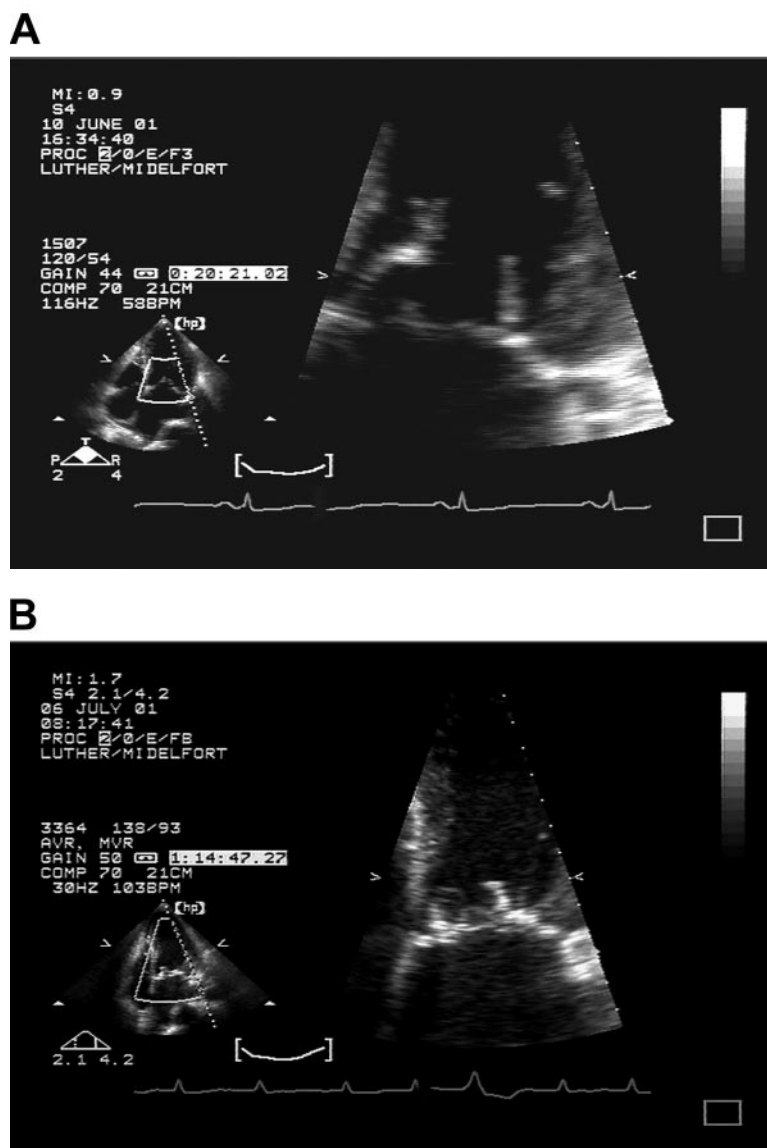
Preoperative transthoracic echocardiogram showing diseased mitral valve (A) paired with a postoperative echocardiogram from same patient showing a properly functioning prosthesis (30-mm Hancock prosthesis; Medtronic) with NextStitch used as the suture material (B). Note that there is no evidence of ring-down or acoustic shadowing related to the NextStitch material.
